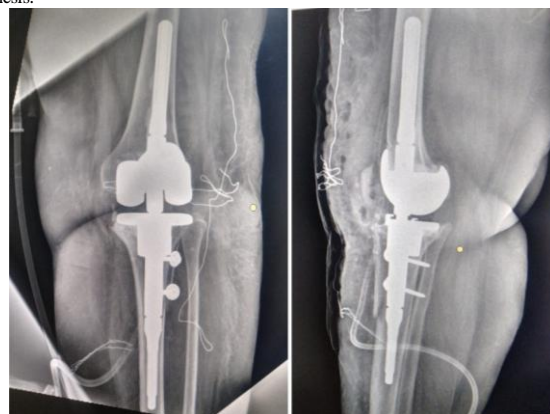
Immediate postoperative x-ray of case 1 showing good alignment of tibial & femoral components.
